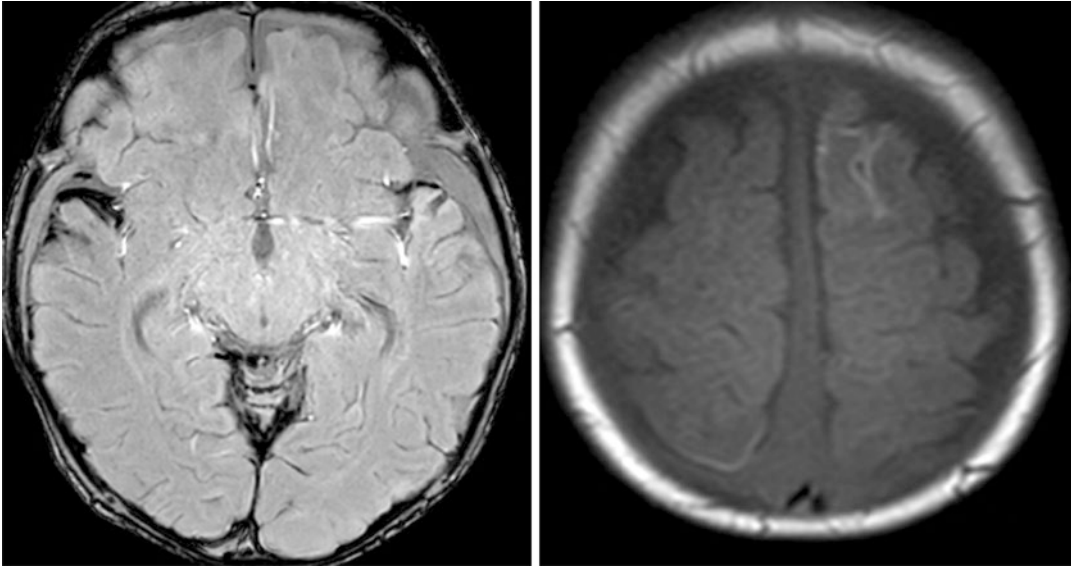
Axial susceptibility-weighted imaging and FLAIR sequence of the brain. Blooming artefact on the susceptibility-weighted imaging demonstrated in both
